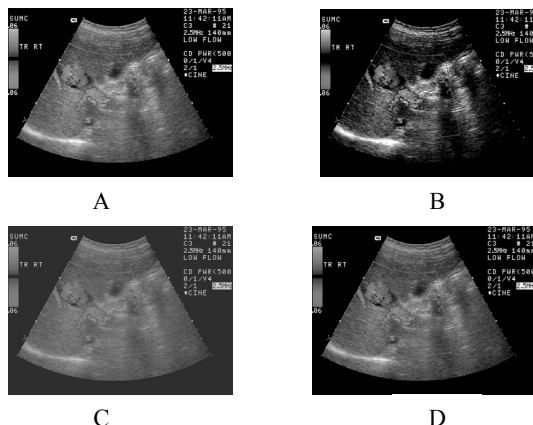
Contrast attack (A) automatic, (B) dark and (C) clear on the original ultrasound (D)
